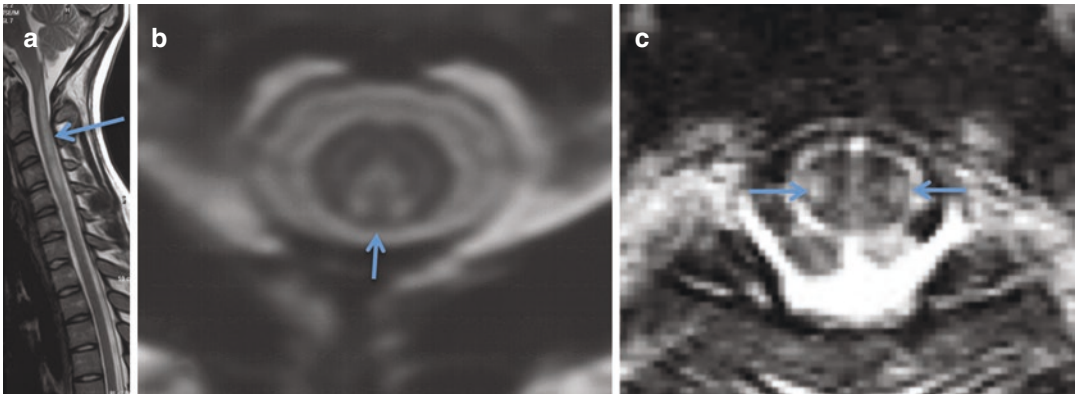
Sagittal (a) and axial (b) T2-weighted TSE images in a 40-year-old woman with loss of vibration sense, spasticity, and hyperreflexia. The T2 hyperintense lesion involves the posterior columns of the cervical
